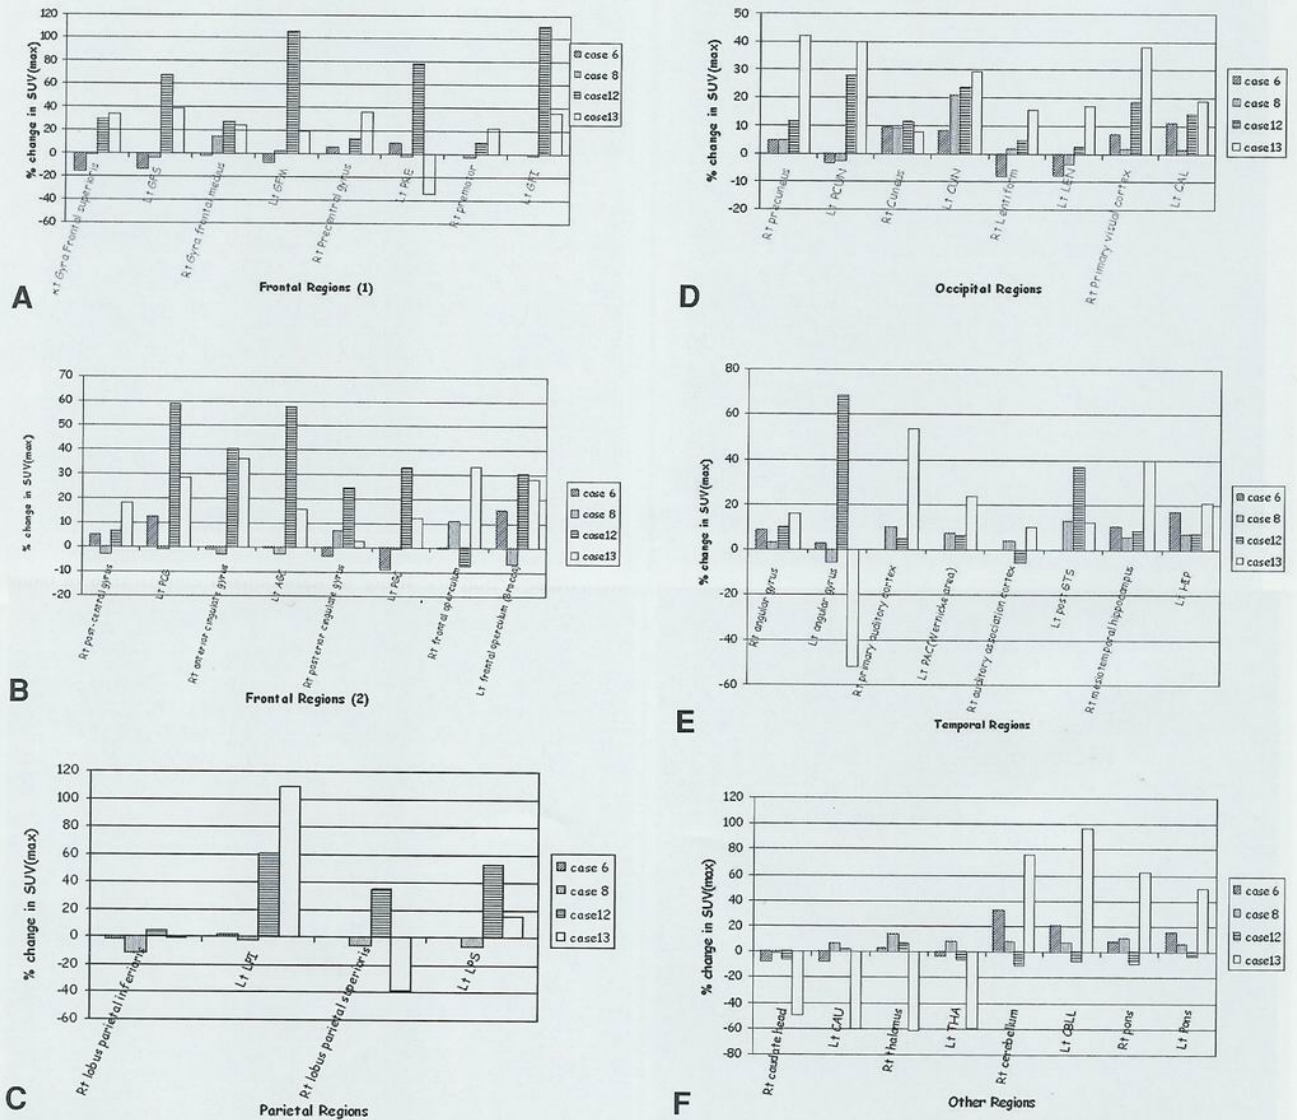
Comparison of percent change in standardized uptake value maximum (SUVmax) for the four cerebral palsy cases. A, Comparison of frontal regions (1). B, Comparison of frontal regions (2). C, Comparison of parietal regions. D, Comparison of occipital regions. E, Comparison of temporal regions. F, Comparison of other regions.
